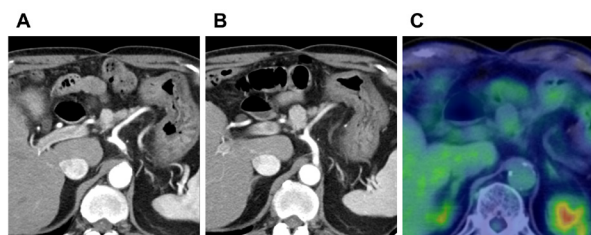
(A) CE-CT revealed a swollen LN 11 mm in diameter with enhancement in the arterial phase (arrow). (B) Three months later, CE-CT revealed enlargement of this LN, which was now 16 mm in diameter, with enhancement in the arterial phase (arrow). (C) PET-CT revealed FDG accumulation in this LN. CE-CT: contrast-enhanced computed tomography, PET-CT: positron emission tomography-computed tomography, FDG: fluorine-18 deoxyglucose, LN: lymph node.
